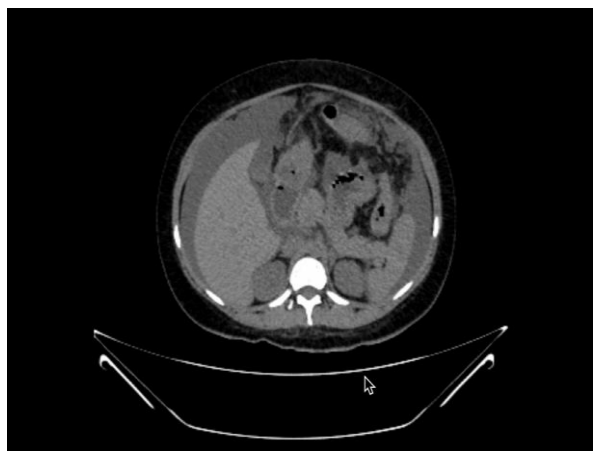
Whole Abdominal CT Scan of the patient showing massive ascites in the perihepatic, pericholecystic, perisplenic, mesenteric, bilateral
